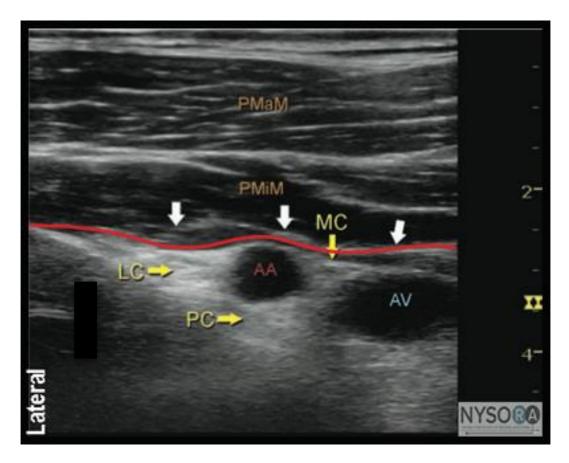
Ultrasound image of the infraclavicular region.
